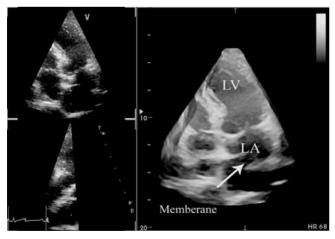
Transthoracic three-D echocardiogram showing the membrane in the left atrial cavity (arrow)
